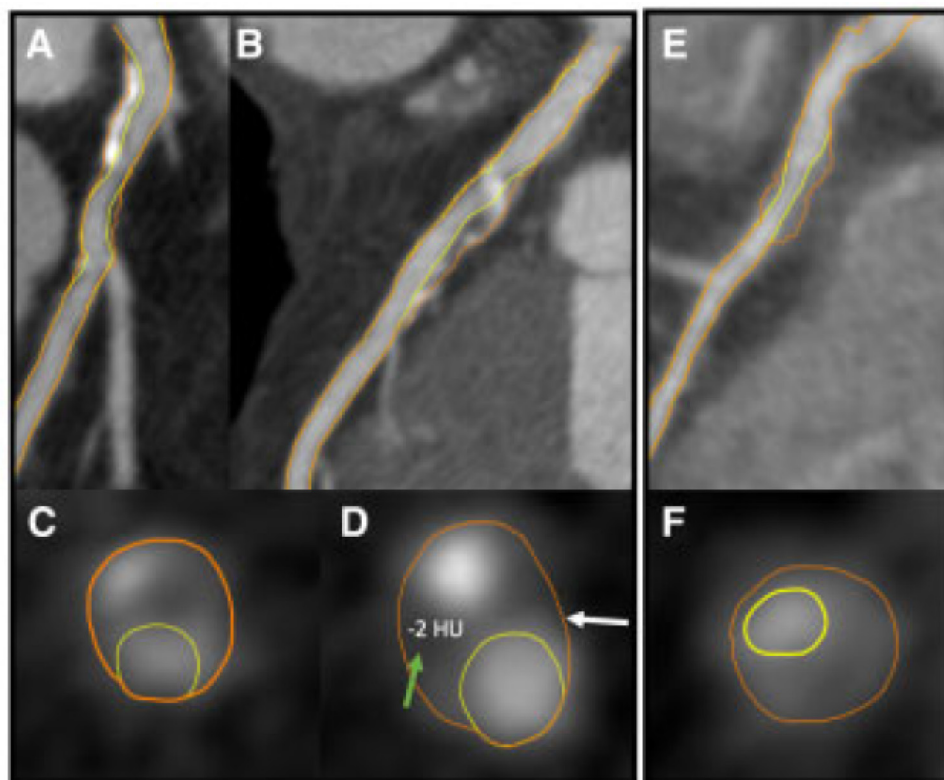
Coronary computed tomography angiograms demonstrating high-risk plaque (HRP) in culprit lesion precursors. A 61-year-old male ex-smoker exhibited a high-risk plaque extending from the (A) left main to the (B) proximal left anterior descending artery with (C) 41% diameter stenosis severity, (D) positive remodelling (white arrow), and low-attenuation plaque (green arrow). There is also diffuse calcification. One month later, the patient presented with a non-ST-elevation myocardial infarction. A 55-year-old male with hypertension and hyperlipidaemia exhibited a high-risk plaque with (E) only 35% DS severity, but (F) positive remodelling, low-attenuation plaque, and napkin-ring sign. The patient presented with a non-ST-elevation myocardial infarction 2 months later. From Ferraro *et al.*³³, by permission of OUP on behalf of the ESC.
